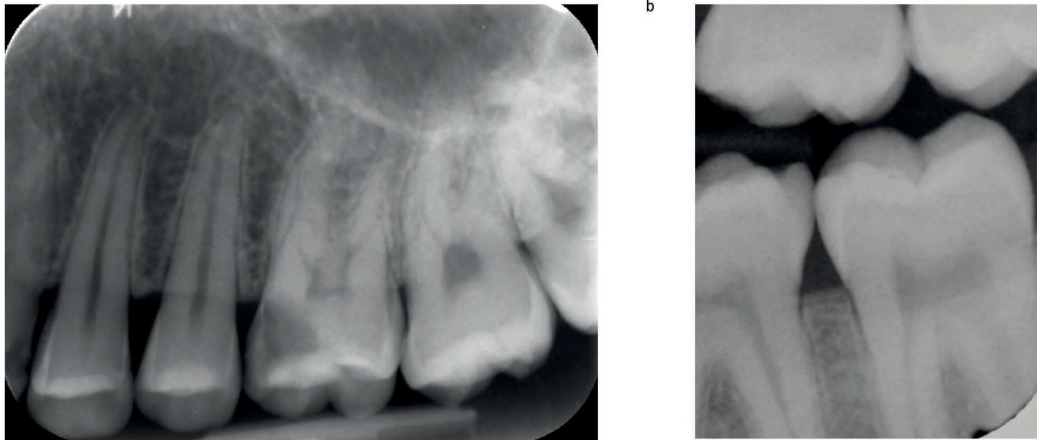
(A) Radiograph of a maxillary left first permanent molar with a deep carious lesion extending to the inner (pulpal) one third of dentine where preservation of pulp health should be prioritised during operative intervention; and (B) a shallow carious lesion in the mandibular left second molar (confined to the inner third of the dentine) where the tooth-restoration complex longevity might have more significance when deciding on the minimally invasive operative management options (Banerjee et al., 2017).
